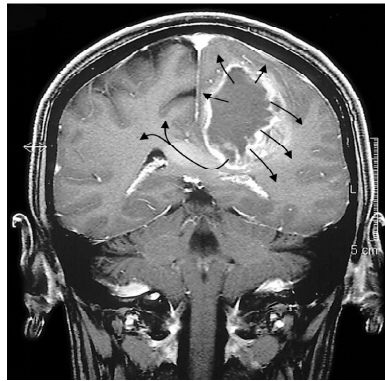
Image obtained by magnetic resonance imaging of a glioblastoma in the left side of the brain. The tumor presented active infiltration into the surrounding areas including the corpus callosum, the arrows indicate the directions of the tumor infiltrative fronte.
